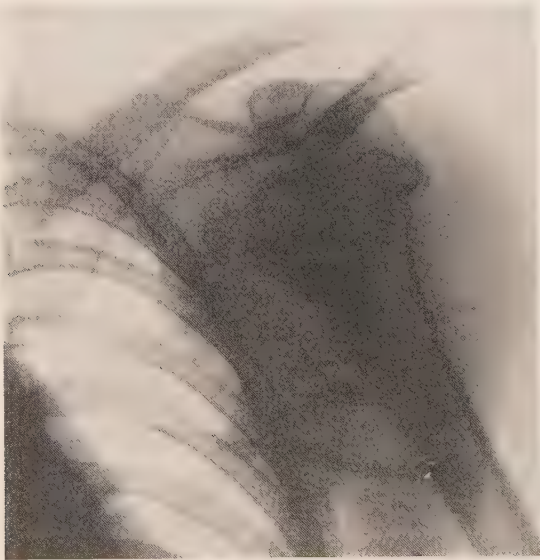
Subcoracoid dislocation of the humerus. (Roentgenogram by Dr. G. C. Bird.)
